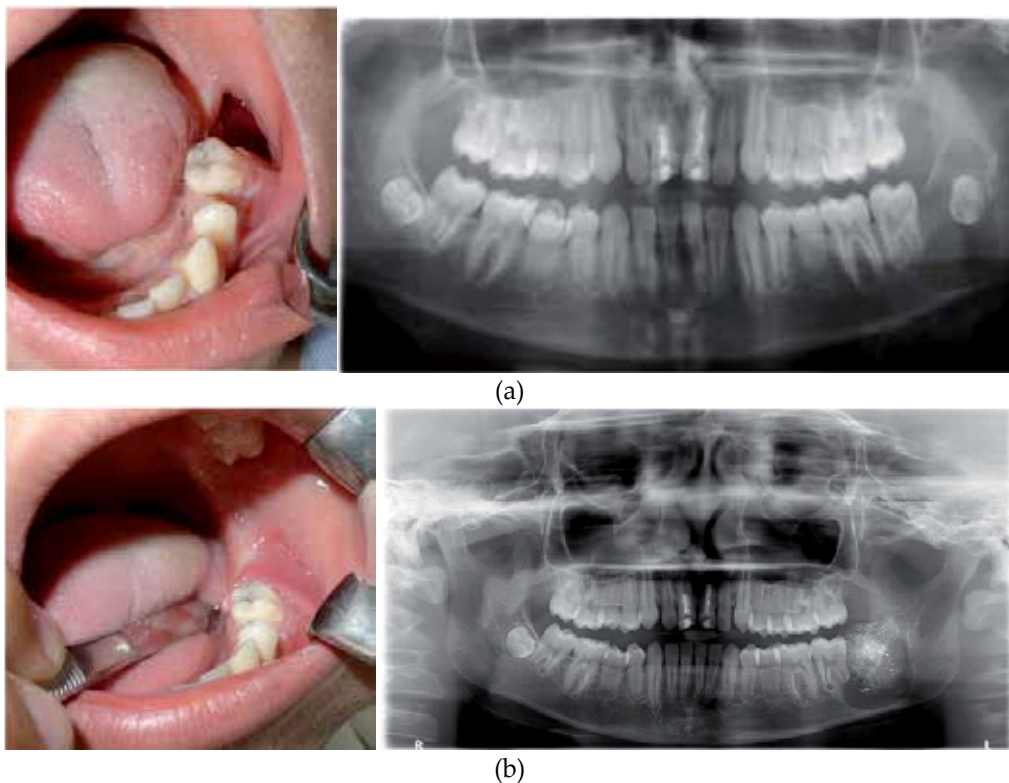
(a): KCOT. Frontal photograph and radiograph showing a 14-year-old boy presenting a posterior mandibular radiolucency associated with impacted left third molar. (b): Oral and radiographic appearance of the operated area with gauze tamponade after cystostomy and application of the surgical obturator.
